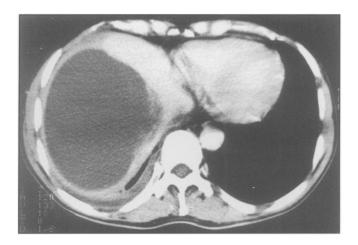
CT scan 10 days post-injury demonstrating a large subphrenic bile collection.
